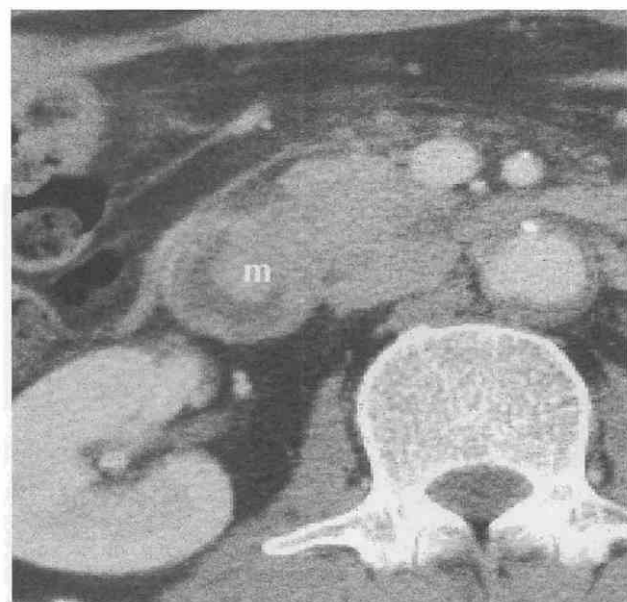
Metastasis to the duodenum from squamous cell carcinoma of the lung. CT scan shows a polypoid mass (m) protruding into the duodenal lumen.
